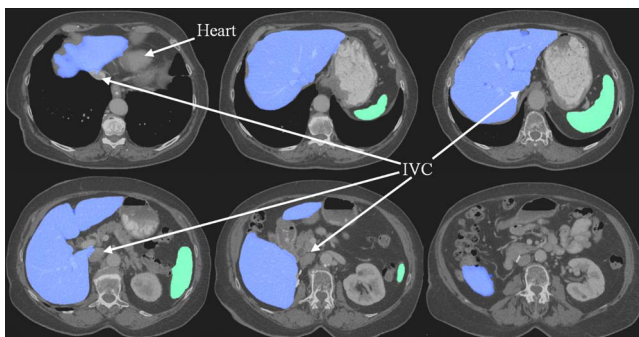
An example of liver and spleen automatically segmented from a normal test case. 2D axial slices of the 3D CT data are shown.
